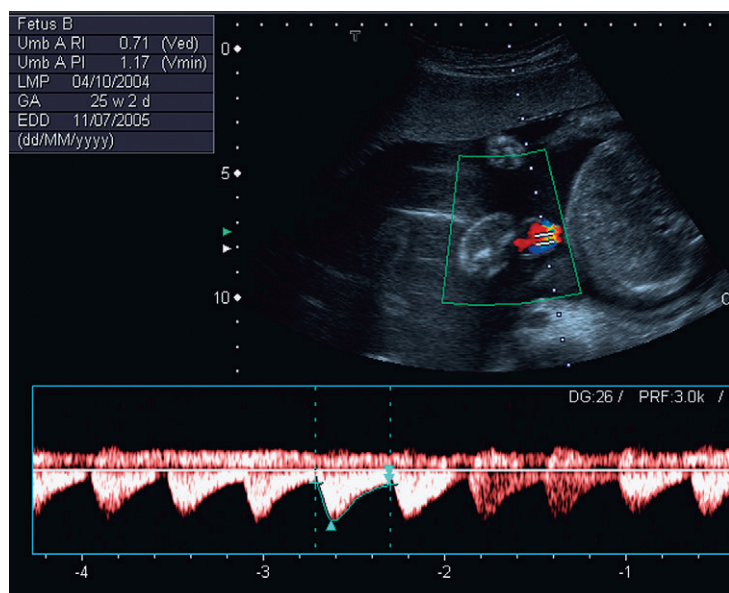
Umbilical Doppler in twin pregnancy.
